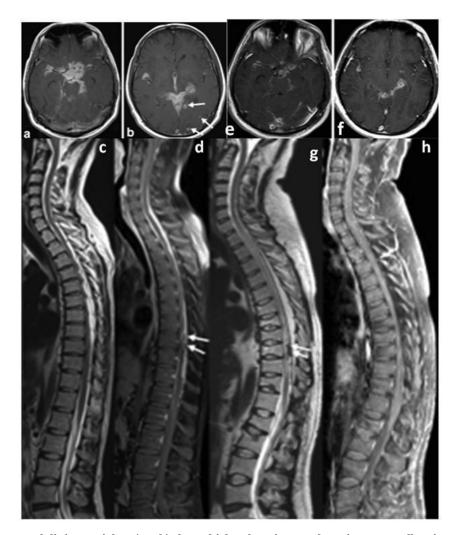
MRI brain post gadolinium axial T1 (a & b) show thick enhancing exudates in supra-sellar cistern, bilateral sylvian fissure, inter-peduncular cistern and bilateral peri-mesencephalic cisterns. Enhancing granulomas (arrows) are present in left occipital and temporal lobes. Whole spine sagittal T2-WI (c) and post-gadolinium T1-WI (d) show thick leptomeningeal enhancement and sub-pial peripherally enhancing granulomas in lower dorsal region (arrows in d) suggesting arachnoiditis. Follow-up post-gadolinium MRI brain T1-WI (e & f) shows) image significant reduction in enhancing exudates and resolution of enhancing granulomas. Follow-up MRI of whole spine-sagittal T2-WI (g) shows mild cord hyperintensity in dorsal region and hypointense granulomas (arrows in g). Leptomeningeal enhancement and enhancement of subpial granulomas has reduced in postgadolinium sagittal T1-WI (h).
